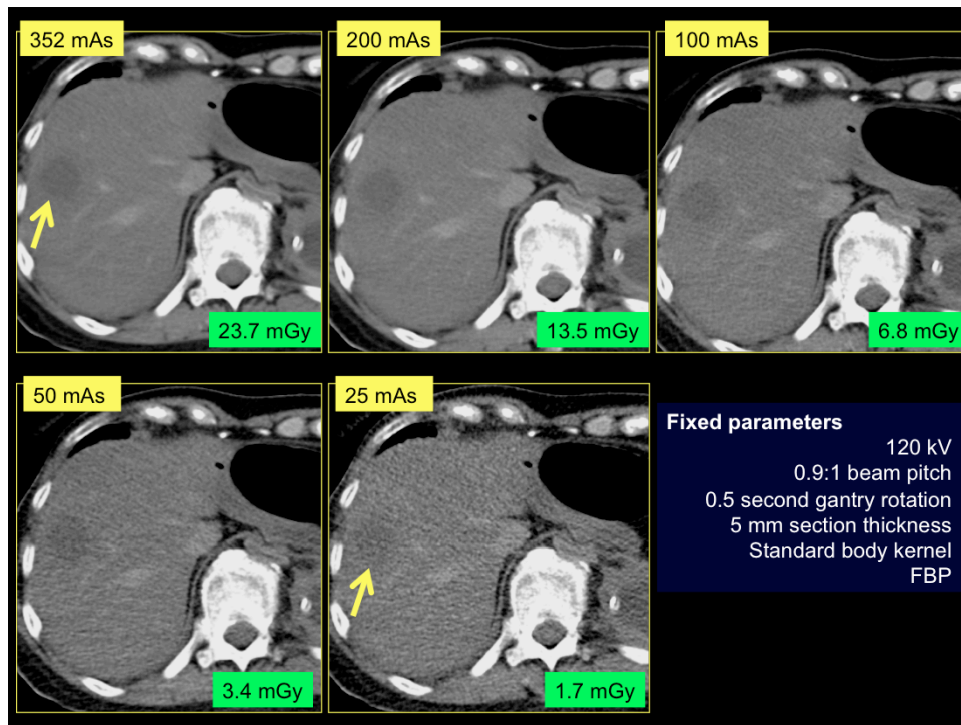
60 year old female (52 kg) with known diagnosis of metastatic papillary carcinoma of thyroid with post mortem abdominal CT at various tube current levels. Lower mAs images have higher image noise and lowered visibility of low attenuation hepatic metastases (arrow) and hepatic vessels.
